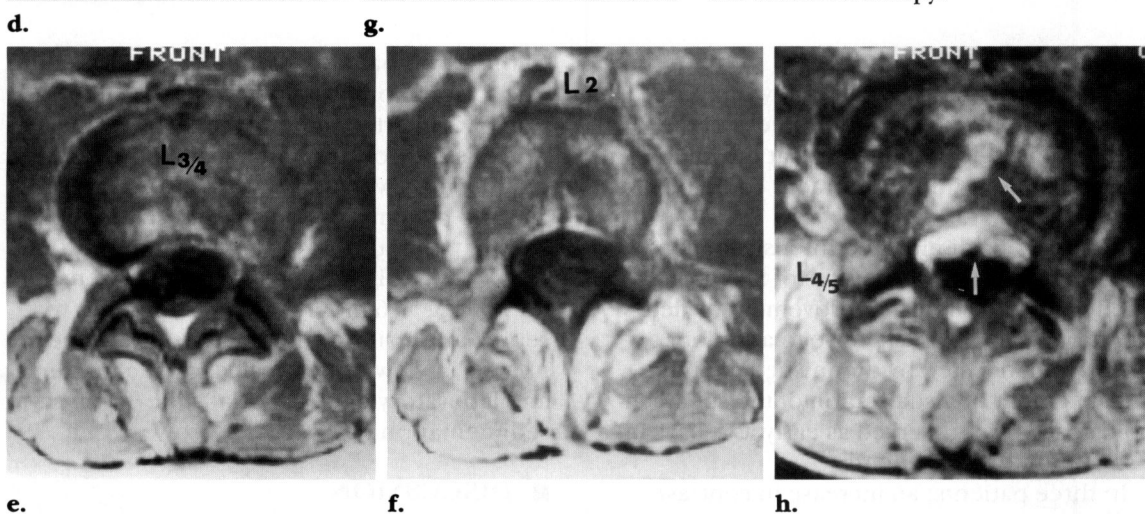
Case 20 (continued). (d-f) On follow-up postcontrast sagittal (d) and axial (e, f) T1-weighted images, abnormal enhancement in the epidural and paravertebral spaces has nearly resolved. Dural sac compression and prominence of the basivertebral veins are no longer seen. There is slight enhancement of the L-3 and L-4 vertebral bodies. Five months later, the patient again developed fever and low back pain. (g, h) Postcontrast sagittal (g) and axial (h) T1-weighted images demonstrate a new lesion at L4-5. There is diskitis with an associated epidural abscess mainly in the anterior epidural space (arrows). Prominent epidural veins are seen at S-1 and S-2 (arrowheads in g). The patient is currently receiving continuous antibiotic therapy.
